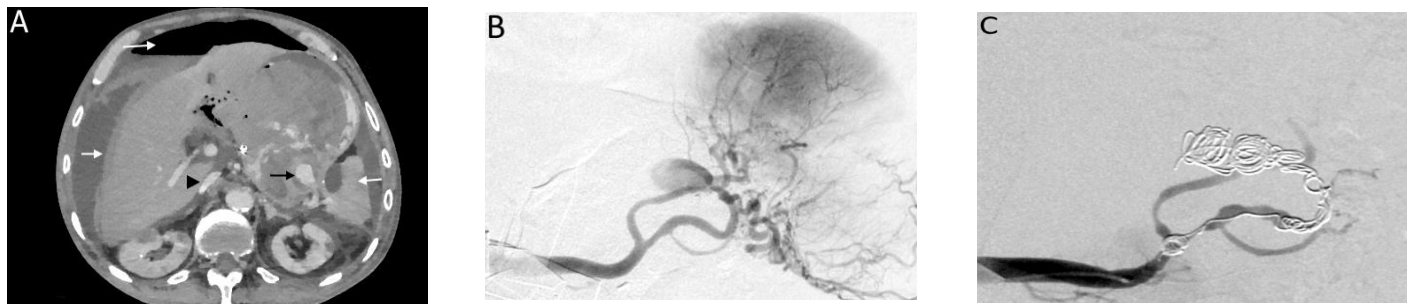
(A) Abdominal CT scan demonstrates large volume active bleeding from posterior wall of gastric fundus (black arrow), blood and clots in massively distended stomach, gastric perforation evidenced by pneumoperitoneum & hemorrhage throughout the upper abdomen (white arrows), flattened IVC due to hypervolemia (arrow head). (B) Late arterial phase DSA of the celiac axis demonstrates opacification of the splenic artery, its branches and spleen parenchyma. Contrast is also filling an ovoid shaped pseudoaneurysm arising from the splenic artery adjacent to the splenic hilum. (C) DSA after embolization demonstrates coils and no contrast within the pseudoaneurysm.
